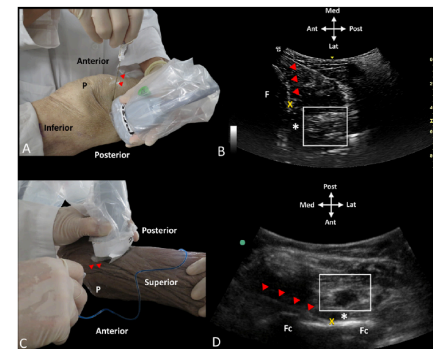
Methodology. Ultrasound-guided proximal and distal infiltration of the interspace between the popliteal artery and capsule of the knee (iPACK) injection techniques. (A) Proximal injection technique. The probe is placed over the anteromedial thigh with needle advancement in the anteromedial to posterolateral direction, approximately 1 fingerbreadth superior to the base of patella. (B) Sonogram showing in-plane proximal needle advancement adjacent to the femoral shaft. (C) Distal injection technique. The probe is placed over the popliteal region with needle advancement, from medial to lateral, at the level of the superior border of the femoral condyles. (D) Sonogram showing in-plane distal needle advancement to reach the intercondylar fossa. Arrowheads (red) indicate echogenic needle; asterisk (white), interspace between popliteal artery and capsule of knee; box (white), location of neurovascular bundle/popliteal fat. F, femoral shaft; Fc, femoral condyles; P, patella; X (yellow), site of needle tip location before injection.
